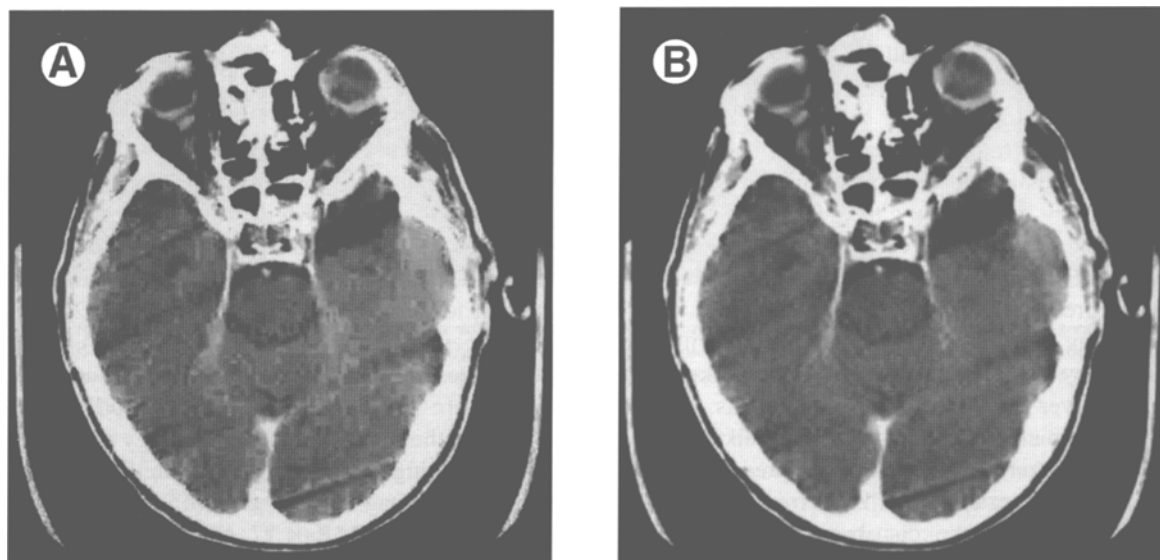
JPEG and wavelet compression artifact. Effects of quantization with JPEG and wavelet compression at 30:1 of the CT image in Fig 1. (A) The two main JPEG artifacts are clearly visible here: the “blocky” effect due to over quantization of the 8×8 blocks of coefficients, and the line artifacts within blocks. (B) Wavelet artifacts that look like “grains of rice” appear due to over-quantization that discards some wavelet coefficients and not others. Note: Our wavelet compression scheme has an option to optimize the compression quality of CT images, which almost completely eliminates the rice effect at 30:1.⁴ That option was turned off for this example to emphasize the quantization effects.
